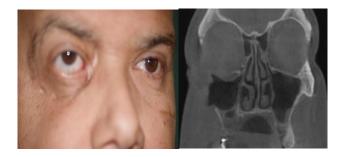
Clinical presentation and CT after chemotherapy.
